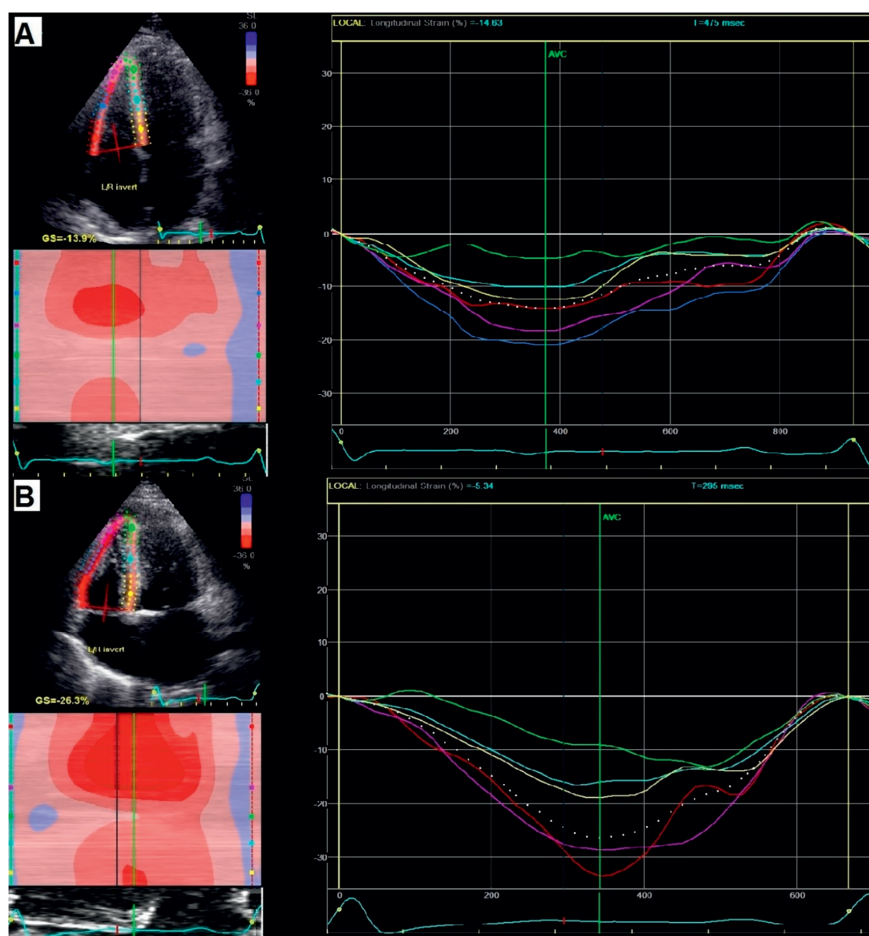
Assessment of right ventricular four chamber longitudinal strain (RV4CLS) by 2D speckle-tracking echocardiography. Panel A. 51-year old patient with impaired RV4CLS of -13.9% who developed severe HF symptoms 3 years later. Panel B. 56-year old patient with preserved RV4CLS of -26.3% who did not experience an event during 8 years follow-up.
